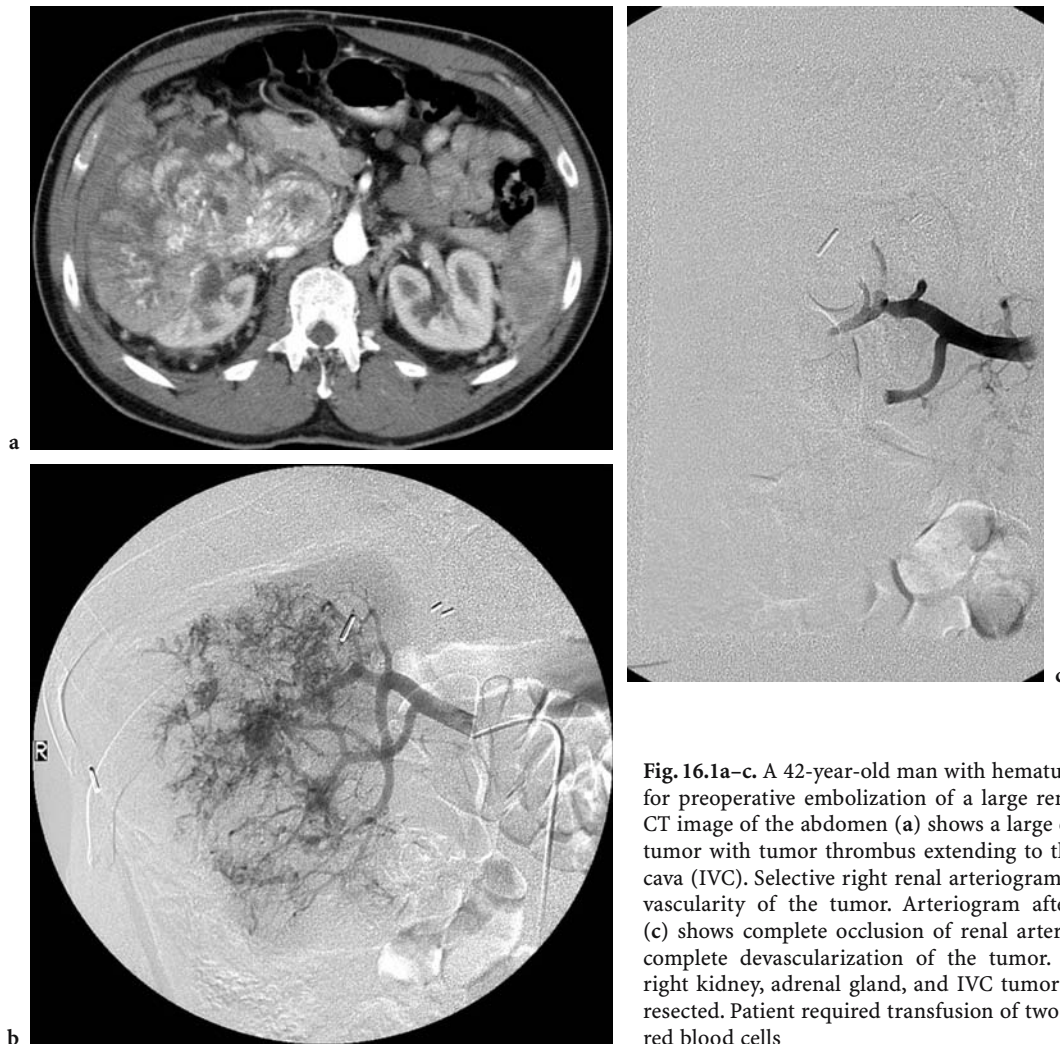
A 42-year-old man with hematuria was referred for preoperative embolization of a large renal tumor. Axial CT image of the abdomen (a) shows a large enhancing renal tumor with tumor thrombus extending to the inferior vena cava (IVC). Selective right renal arteriogram (b) shows neovascularity of the tumor. Arteriogram after embolization (c) shows complete occlusion of renal artery branches and complete devascularization of the tumor. At surgery, the right kidney, adrenal gland, and IVC tumor thrombus were resected. Patient required transfusion of two units of packed red blood cells
